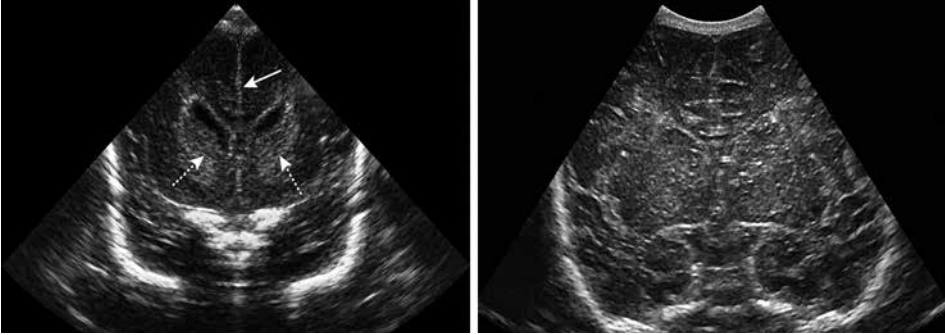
Coronal ultrasound scans at the level of the frontal horns in (A) very preterm infant (gestational age 26 wk) and (B) full-term infant. Showing a very smooth interhemispheric fissure (arrow) and lack of cortical windings in (A), as compared to complexly folded interhemispheric fissure and multiple cortical windings in (B). Also showing diffuse, subtle echogenicity in the basal ganglia (dotted arrows) in (A), being a normal finding in preterm infants.
